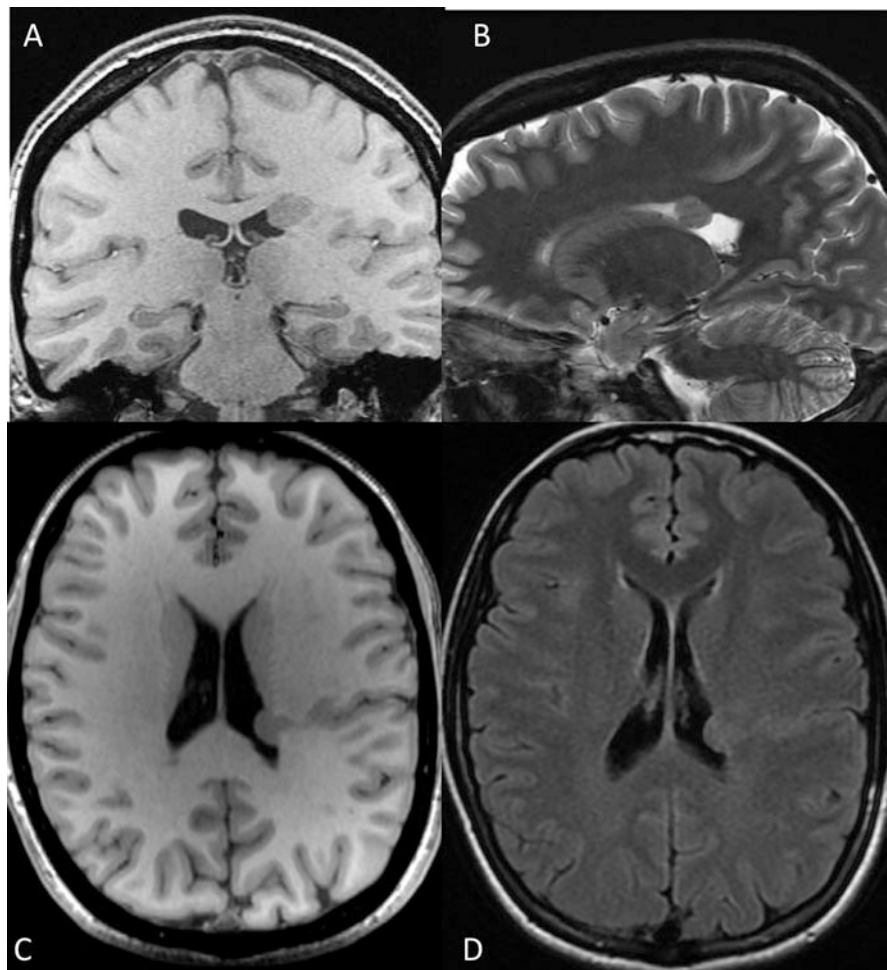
Subependymal nodular gray matter heterotopia with a signal strictly identical to that of the cortex on T1 (a, c), T2 (b), and FLAIR (d) sequences
